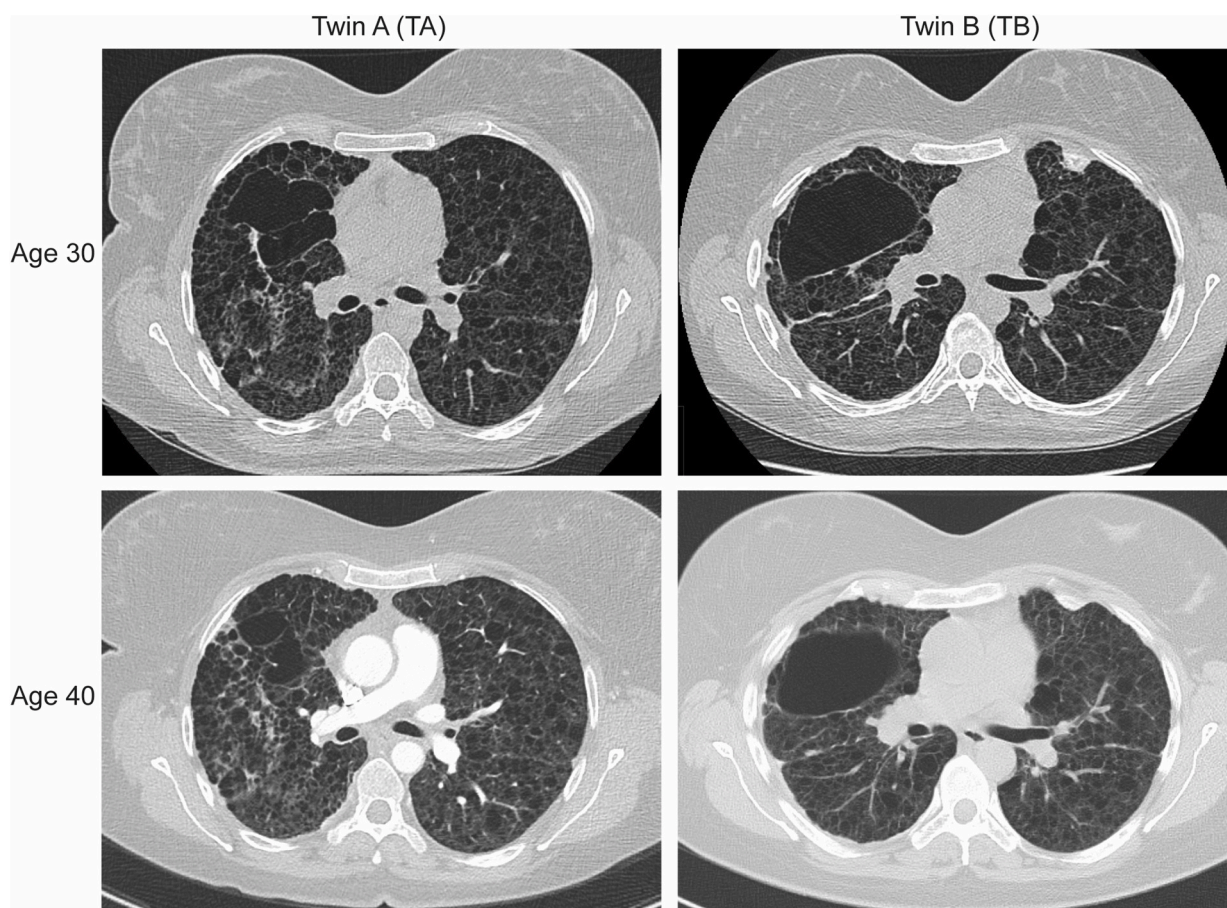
Thoracic CT scan of the twins at diagnosis (age 30) and after ten years follow-up (age 40), respectively.
